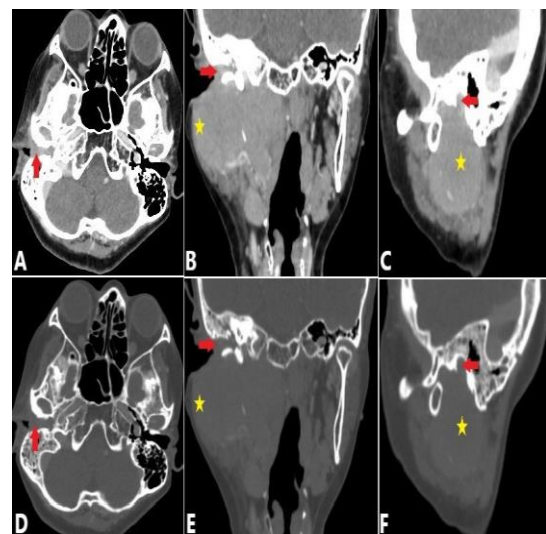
Contrast-enhanced computed tomography scan of the head and neck includes soft tissue (Figures A-C) and bone windows (D-F) in axial (Figures A and D), coronal (Figures B and E) and sagittal views (Figures C and F), showing a homogeneous enhancing mass at the right external auditory canal (arrow), extending to the middle ear, parotid gland (star), parapharyngeal space, masticator space, and temporomandibular joint with erosion of the lateral plate of pterygoid bone and skull base
